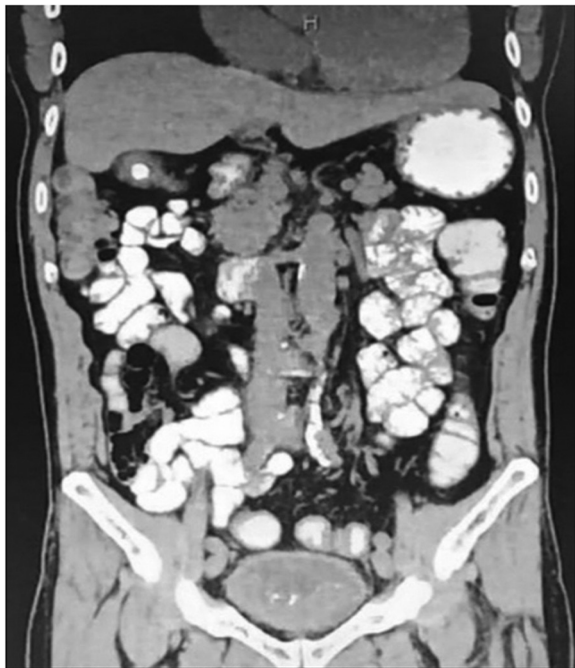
CT scan abdomen coronal view showing diffusely thickened urinary bladder wall and a fungating mass with calcifications in the bladder base 4.6cm in widest AP diameter.
